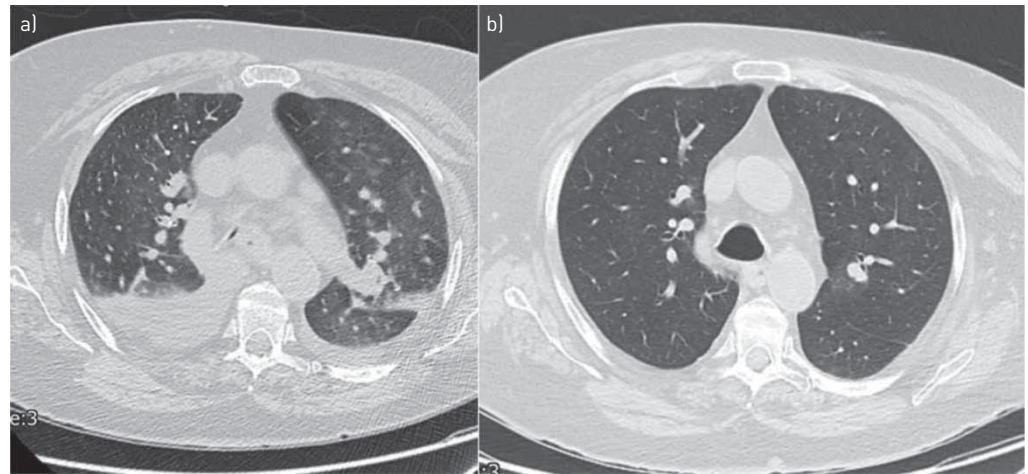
a) Patient with admission computed tomography (CT) chest showing near complete collapse of trachea and pleural effusions. b) Repeat CT after treatment with high-dose corticosteroids with improvement in trachea and resolution of pleural effusions.
